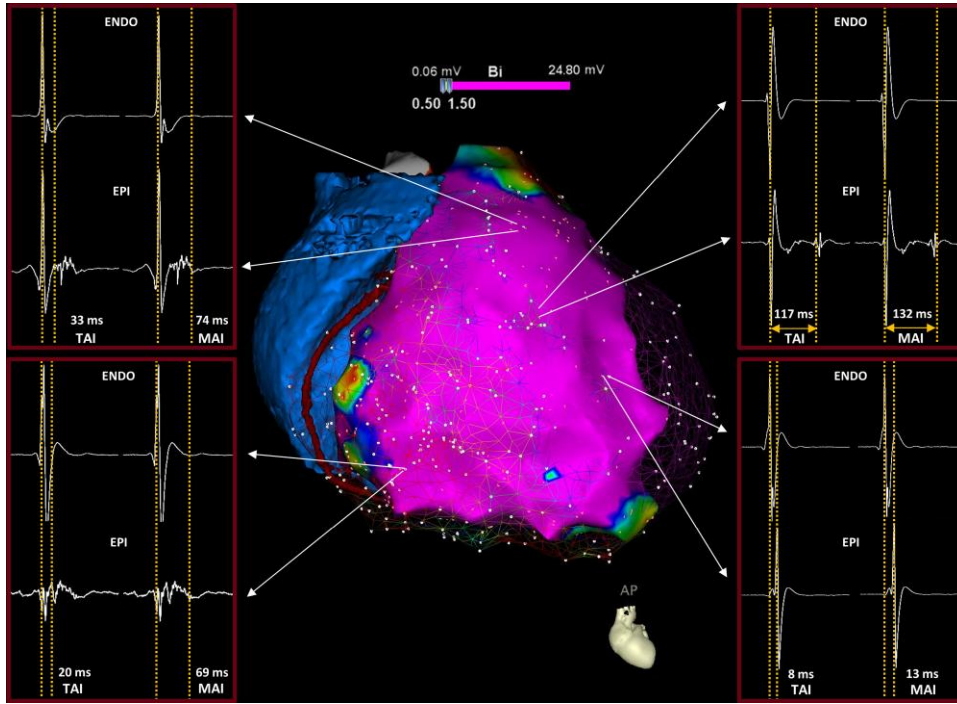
Prolonged TAI in an ARVC patient. An endocardial electroanatomical map is colour coded for bipolar voltage (BV), and the corresponding epicardial BV map is displayed in a mesh view to show the proximity of coupled endocardial and epicardial point pairs. Also, the CT derived cardiac anatomy is integrated with the electroanatomical maps. The lower panels show the transmural activation measurements at two coupled point pairs with the endocardial (MAP 1–2 ENDO) and epicardial (MAP 1–2 EPI) bipolar electrograms. The left two panels show a prolonged transmural activation interval (TAI) and a similarly prolonged maximal activation interval (MAI) due to a prolonged transmural activation delay, without significant inlayer activation delay. The right two panels show a prolonged TAI and a further prolonged MAI due to a combination of transmural and inlayer activation delay.
